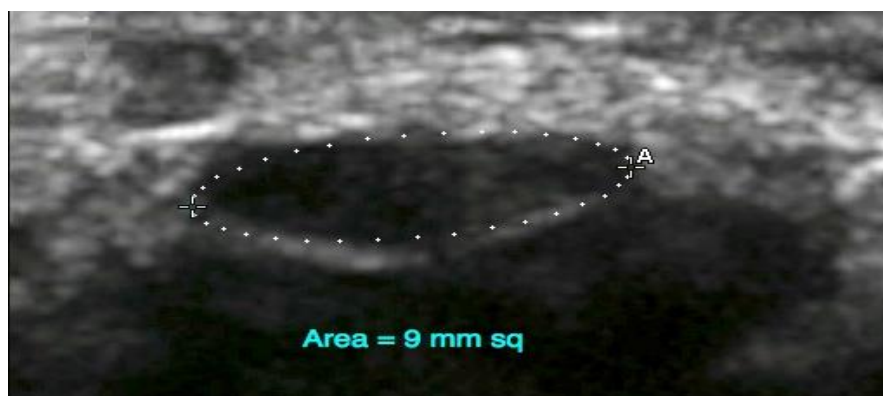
Transverse ultrasonographic image of median nerve (outlined) at level of carpal tunnel (CT) inlet
